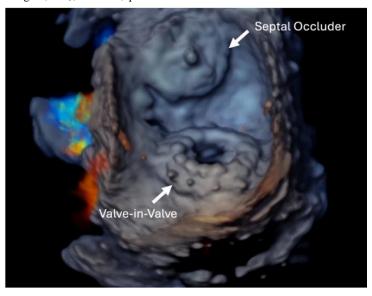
3D transesophageal echocardiogram showing the occluder device in the interatrial septum and the prosthesis in mitral position (Valve-in-Valve).
